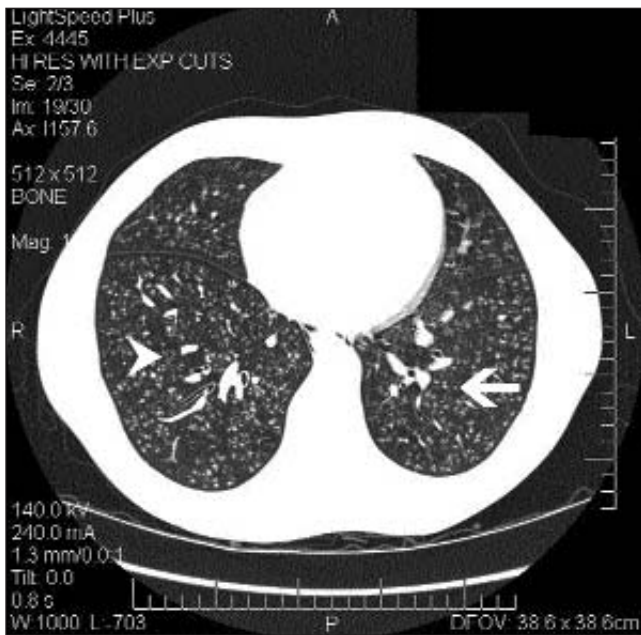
High resolution computed tomography image taken the morning after hospital admission. Note the diffuse centrilobular micronodularity (arrow) and branching linear opacities (arrowhead) characteristic of the 'tree-in-bud' pattern
